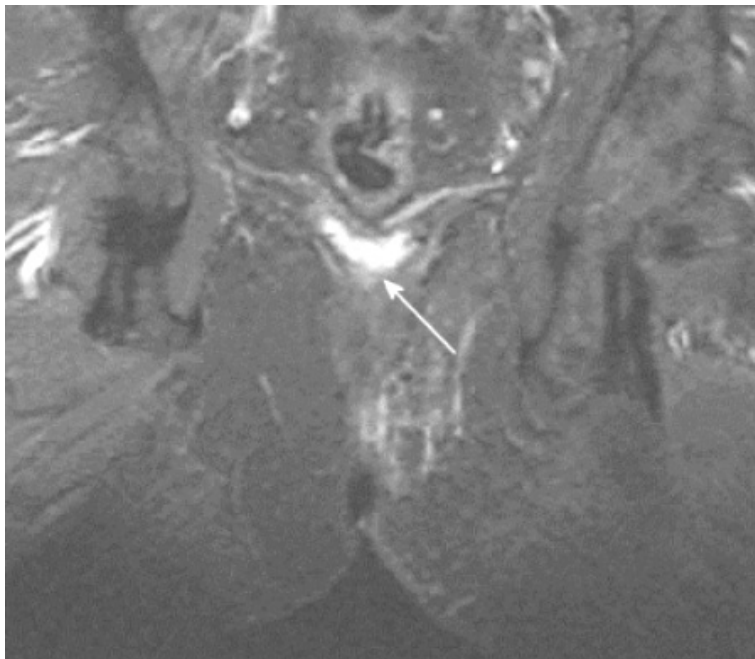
MRI of fistula-in-ano
